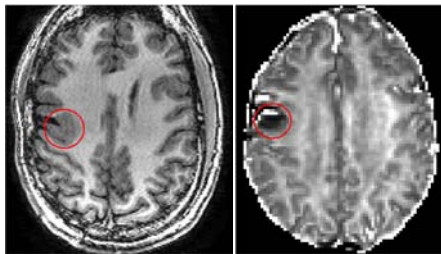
FCD with previous partial resection - T1-weighted image (left), reduced intracellular volume fraction (right)
